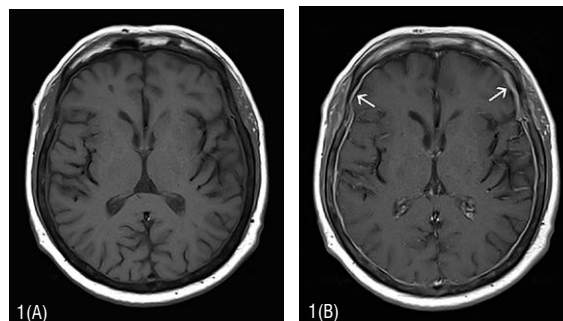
(A) Non-enhanced transverse T1 weighted MR image shows diffusely low signal intensity of the skull bone marrow, compatible with metastatic disease; 1(B) Enhanced transverse T1 weighted MR shows diffusely thickened dura over cerebral convexities with significant uptake of contrast (arrows), associated with mild inhomogenous enhancement of the skull bone marrow
